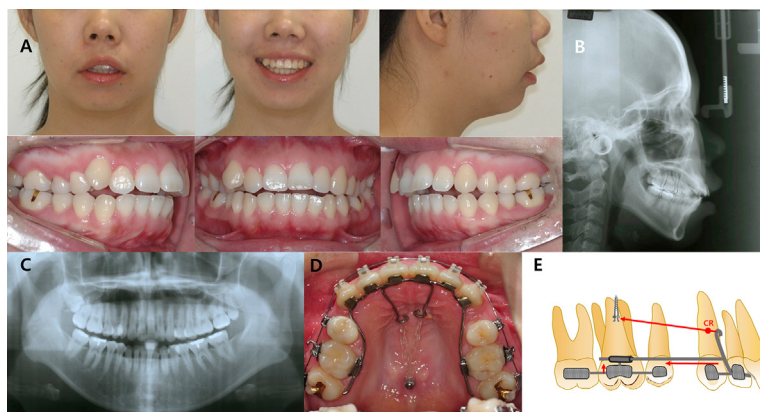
Case 3. Pretreatment data. A: Facial and intraoral photographs, B: Lateral cephalogram, C: Panoramic radiograph, D: Occlusal photo showing the design of the APLR, E: Biomechanics of the APLR.
